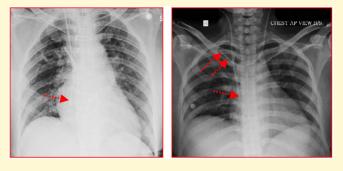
Frontal Chest Radiographs showing Central Line not insitu (A) tip is in Right Atrium, (B) right sided Central line tip is in right atrium and left sided central line tip is in right Subclavian vein.
